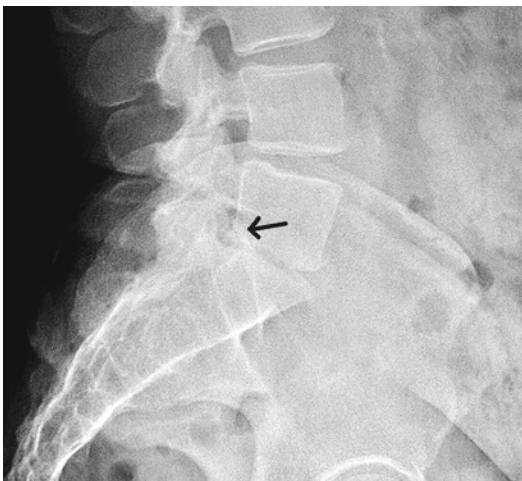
Standing lateral radiograph shows 3 mm of retrolisthesis at L5–S1 (*arrow*)
